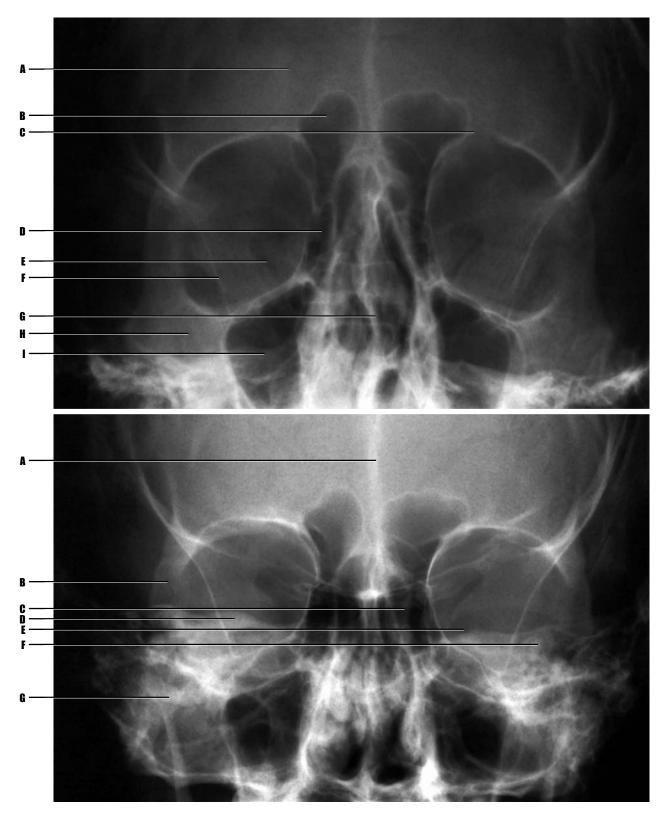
Adult patient, plain film radiograph, "Caldwell view" of sinuses. Image 2.16 Adult patient, plain film radiograph, posteroanterior view of sinuses.
